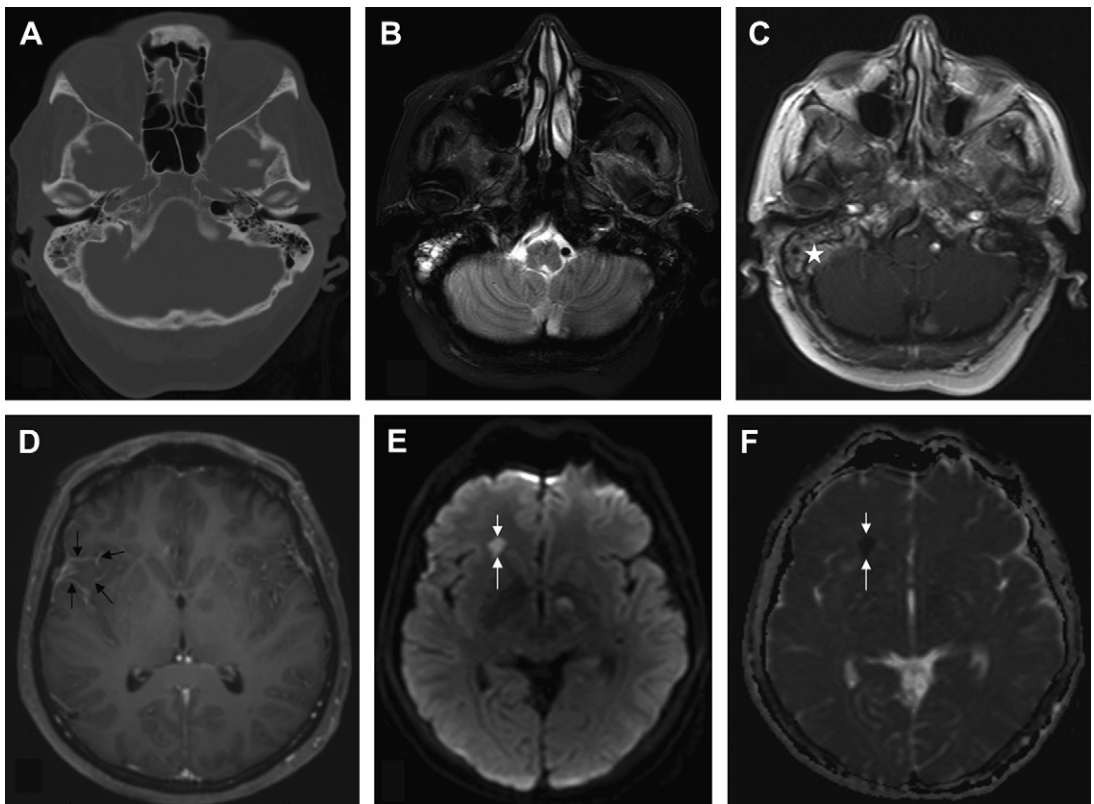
Right-side mastoiditis in a 25-year-old man with meningitis and cerebritis. Axial CT (A), T2-weighted MR imaging (B) and postcontrast T1WI (C, D) showing right mastoiditis (*white asterisk*), with focal leptomeningitis in the right sylvian cistern region (*black arrows*). Focal area of cerebritis (*white arrows*) is seen in the right frontal lobe, with restricted diffusion on DWI (E) and ADC map (F); no obvious enhancement is seen on postcontrast image (D).
